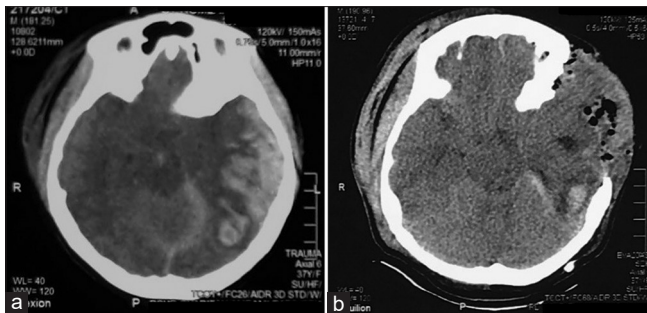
Head computed tomography scan without contrast. (a) Before craniotomy (b) after evacuation and decompression craniotomy
